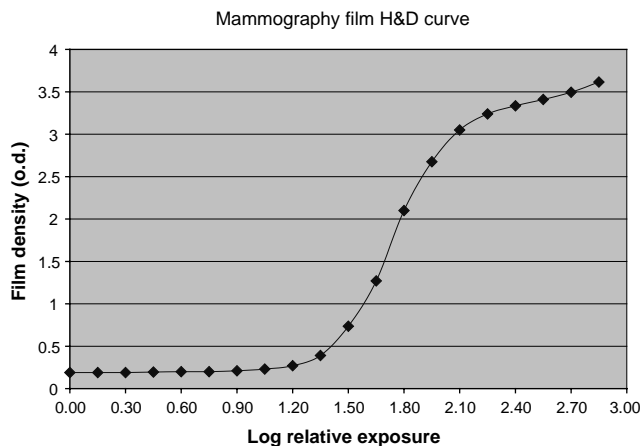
An example of H&D curve of an X-ray film.
